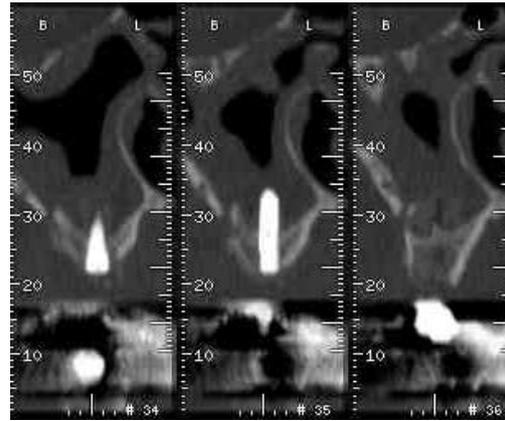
Cross-sectional view of CT scan at # 16 showing grafted CGF in the new compartment of maxillary sinus.
